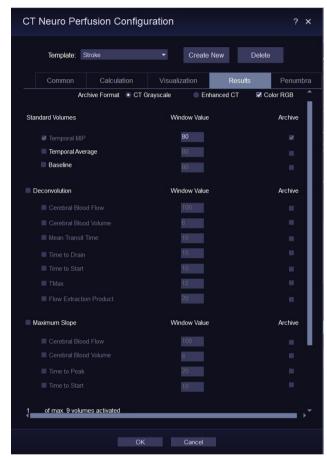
CT Perfusion parameter selection on *syngo*.CT Neuro Perfusion
